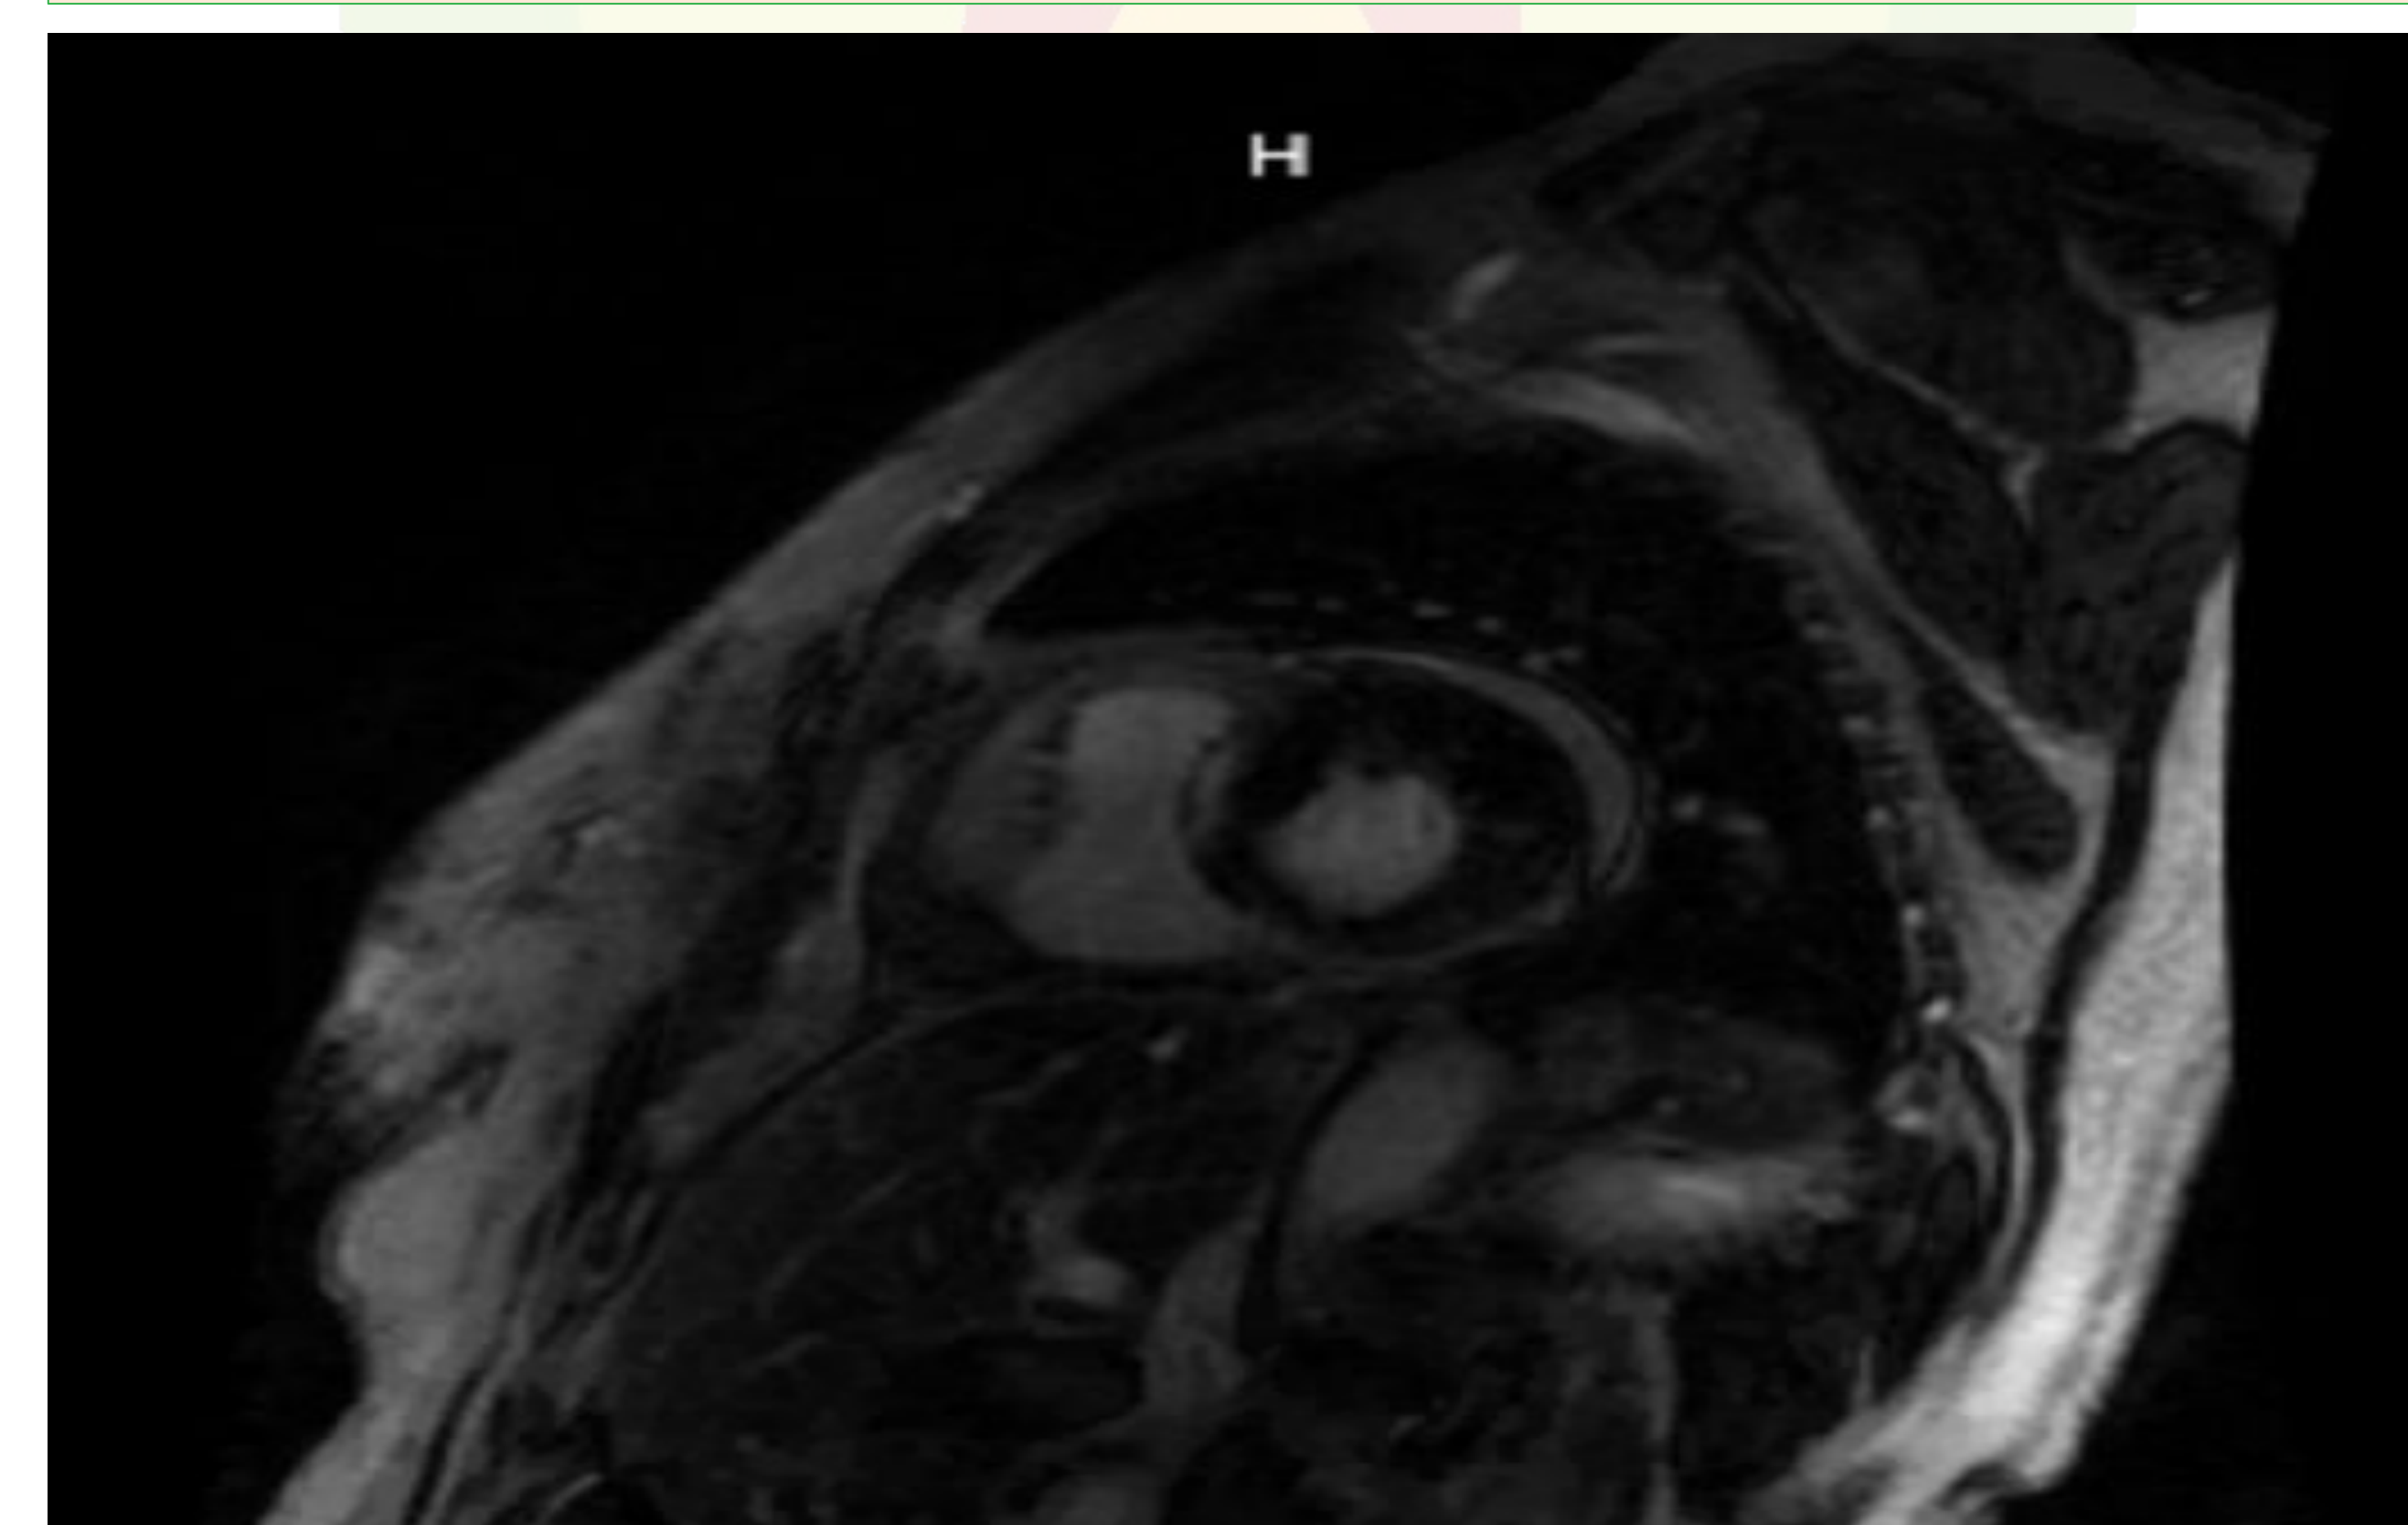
Cardiac MRI. On late gadolinium enhancement imaging, there is myocardial fibrosis in the mid-myocardium of the basal anteroseptal wall.
